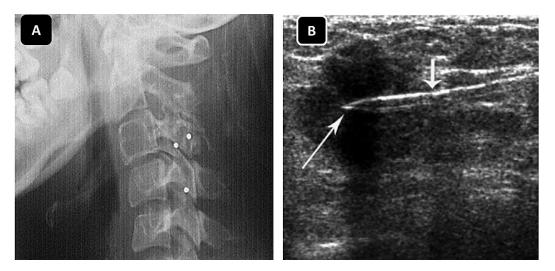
A) an example three gold sphere markers implanted into the vertebral bodies [147], and B) a breast sonogram showing an introducer and radiopaque clip marker in a solid mass [148].
